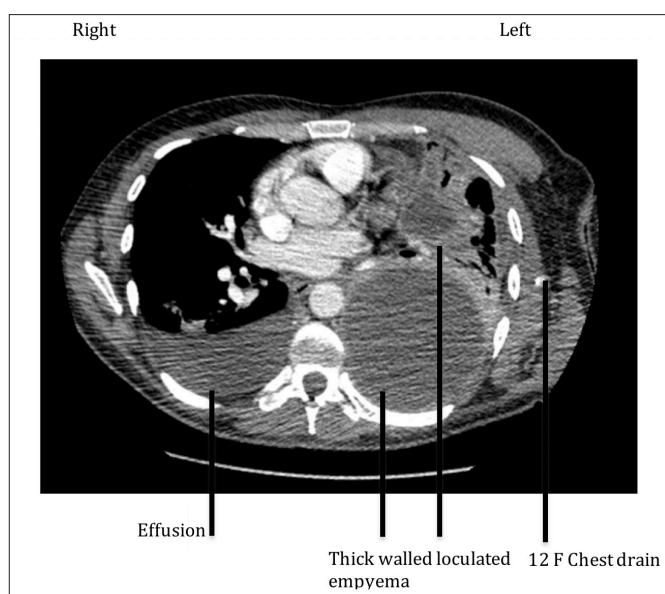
Second CT chest showing right sided effusion and loculated empyema
